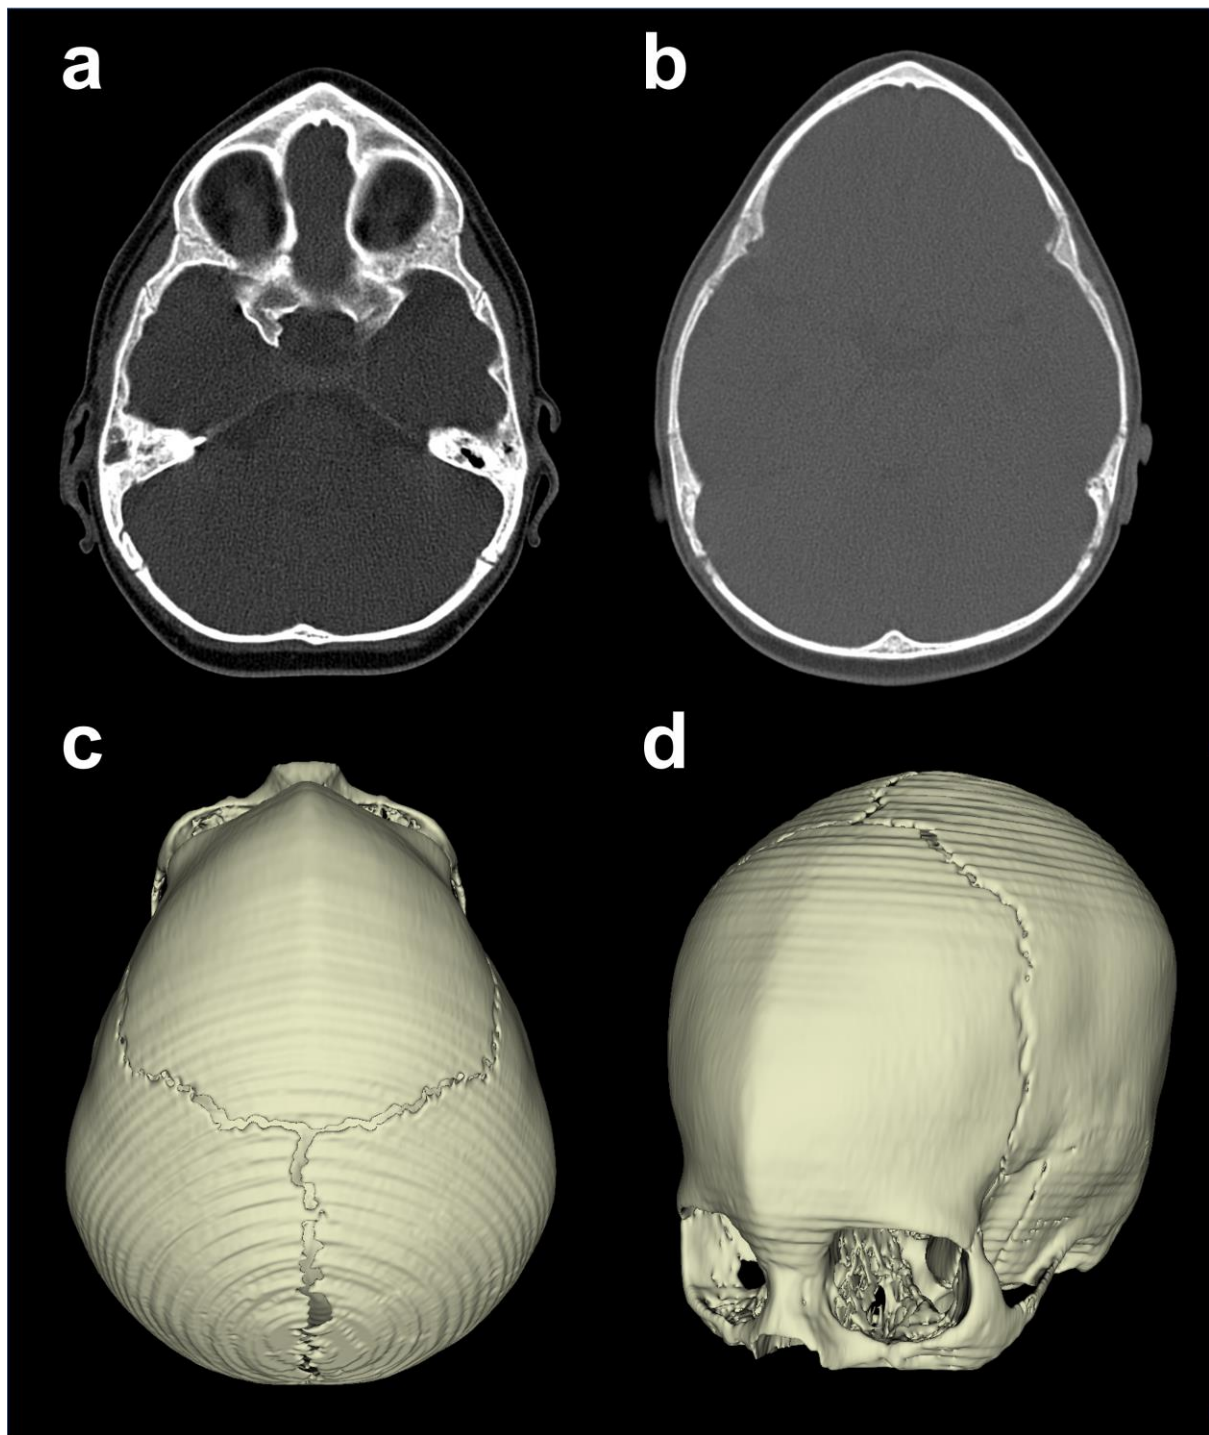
Axial CT slices and 3D reconstruction of the cranium of a patient with metopic craniosynostosis. The fusion of the metopic suture and severe trigonocephaly deformation can be observed.
